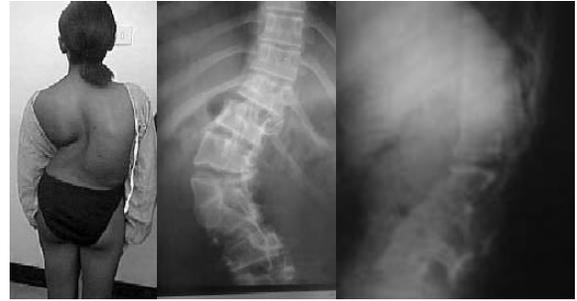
Thirteen years old girl with Congenital Scoliosis (right) at Thoraco-Lumbar region. Xrays (right and center) showing formation and segmentation defect of L1, L2 vertebral bodies.
